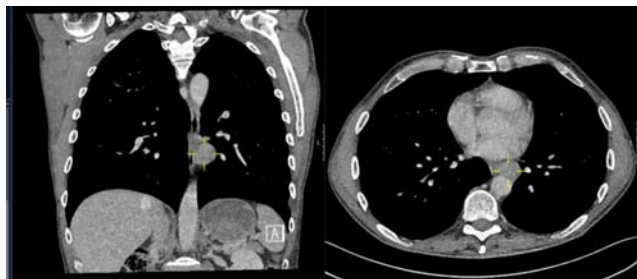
CT scan showing 2.1 cm left paraesophageal mass in close connection with the aorta and pulmonary vein.
